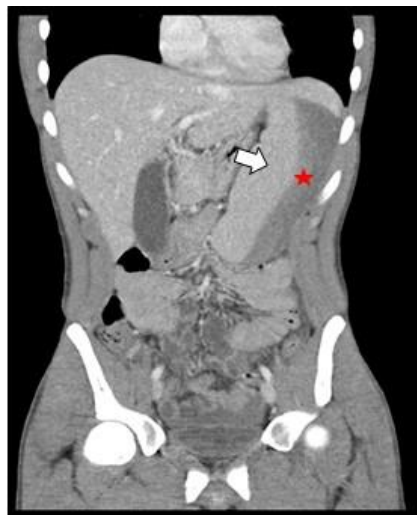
Abdominal CT scan after injection of contrast product – showing an enlarged spleen (white arrow) and its rupture (red star)
